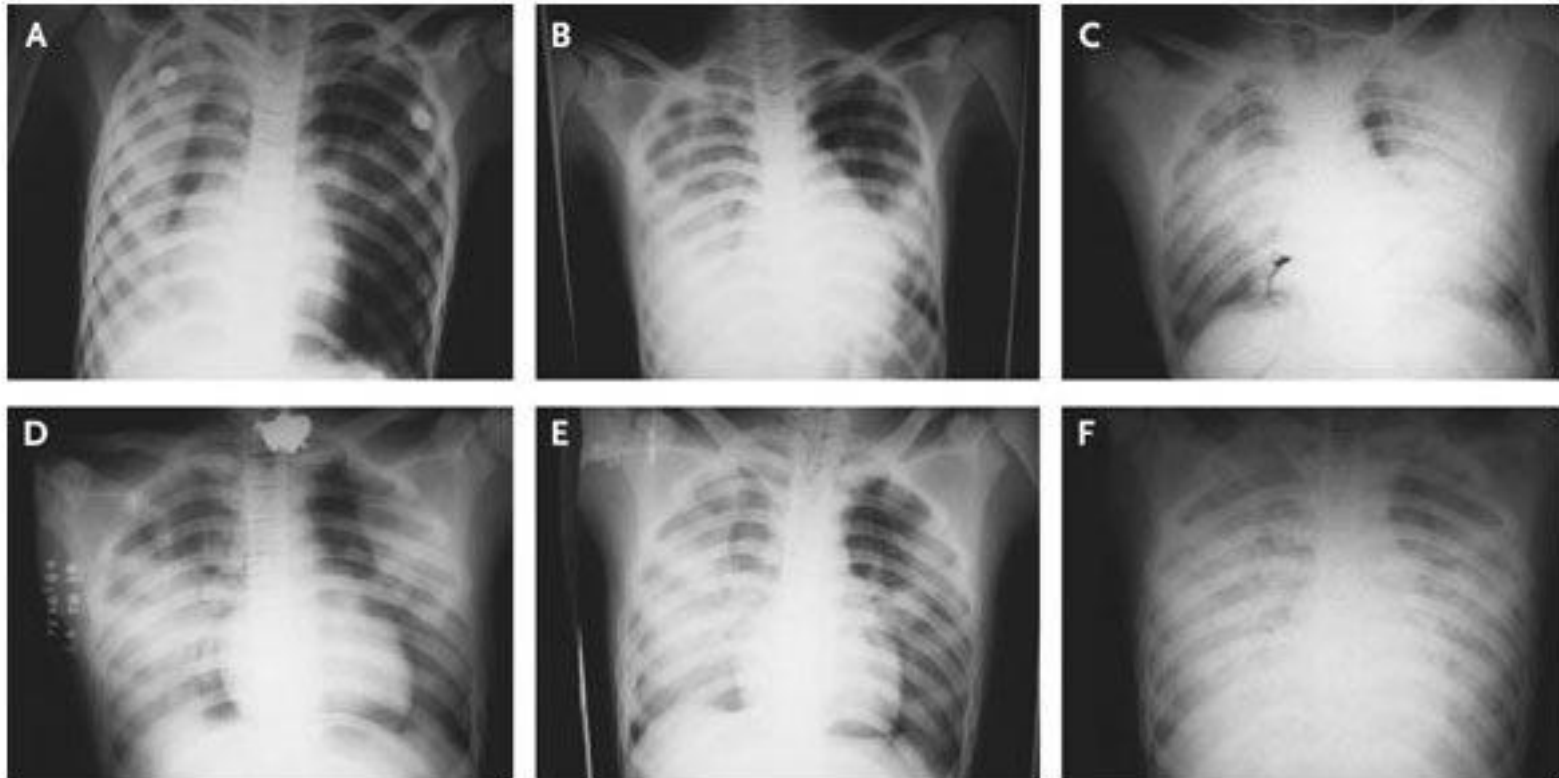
Chest Radiographs.
